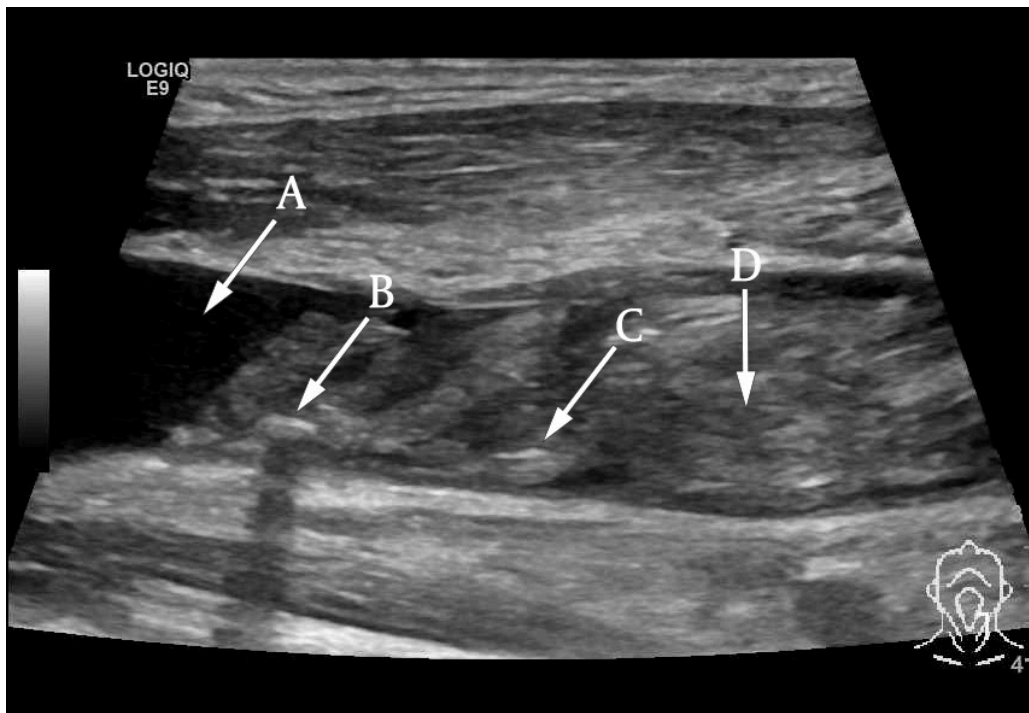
Ultrasound visualisation of an almost totally occlusive thrombus in the left internal jugular vein, longitudinal section. Free lumen (arrow A) can be seen to the left of the thrombotic mass (arrow D). Arrows B and C indicate air bubbles.
